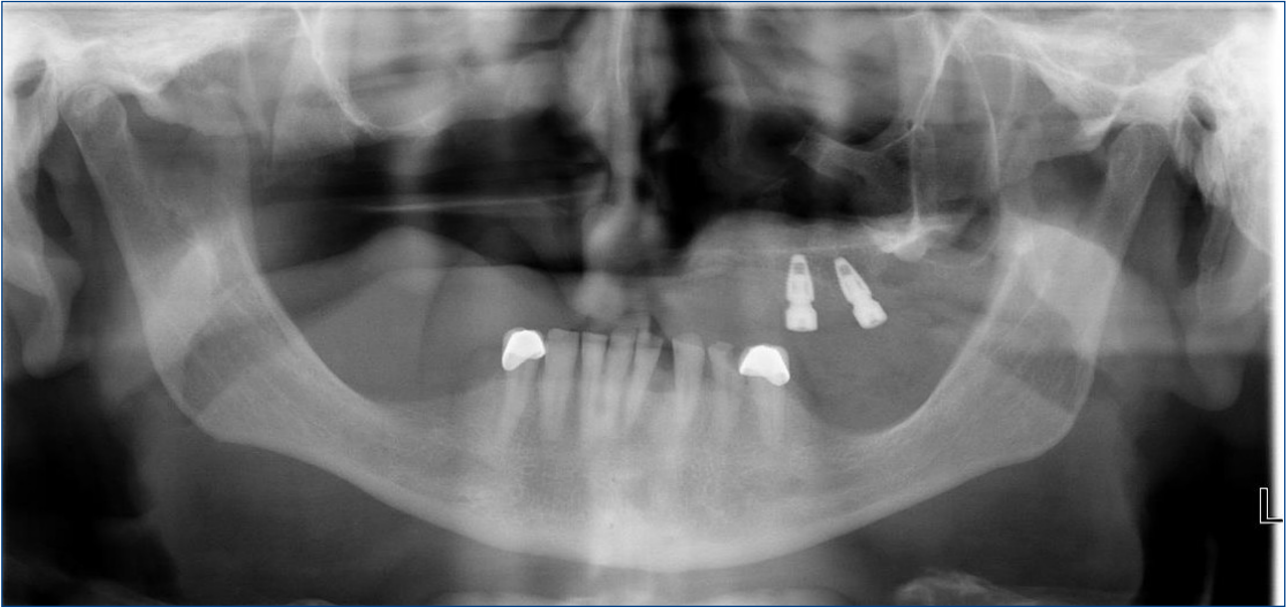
Postoperative 6-month panoramic radiograph of the patient
